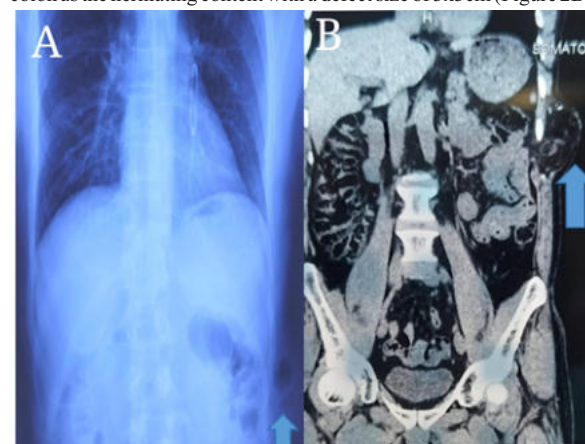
A- Xray showing protrusion of hollow viscus between the ribs. B- NCCT Abdomen showing the same
